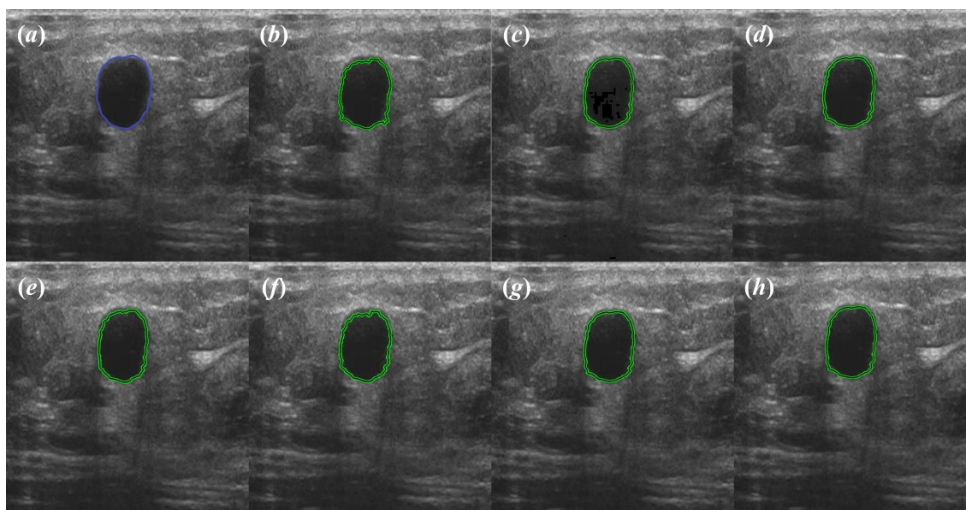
Segmentation of benign tumor from breast ultrasound images (a) Original image indicating tumor boundary marked by the radiologist, (b) Original image indicating tumor boundary obtained after segmentation, (c) Despeckled image using Lee Sigma filter indicating tumor boundary obtained after segmentation, (d) Despeckled image using FI filter indicating tumor boundary obtained after segmentation, (e) Despeckled image using FB filter indicating tumor boundary obtained after segmentation, (f) Despeckled image using HFB filter indicating tumor boundary obtained after segmentation, (g) Despeckled image using BayesShrink filter indicating tumor boundary obtained after segmentation, (h) Despeckled image using DPAD filter indicating tumor boundary obtained after segmentation.
